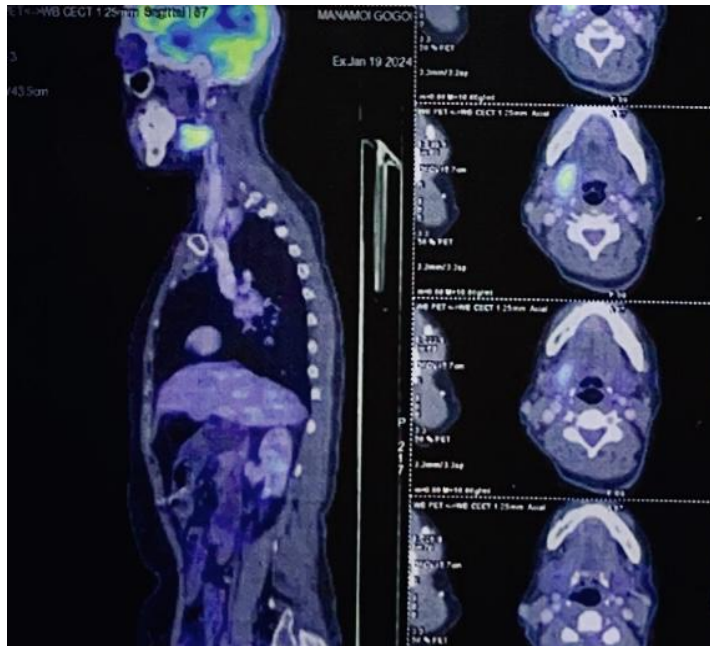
C: Whole Body PET-CT showing FDG uptake in the Right Submandibular region
